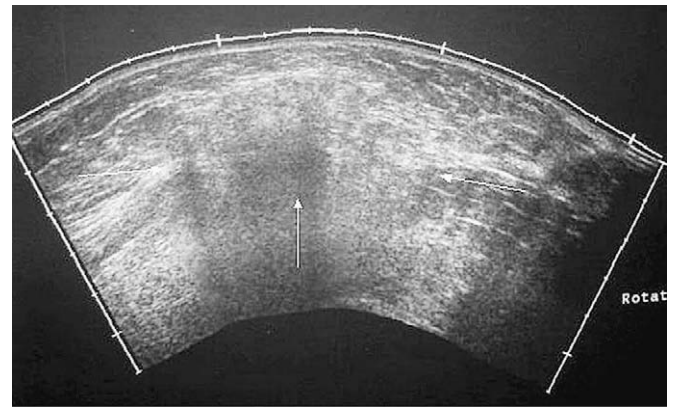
Longitudinal EFOV sonogram showing herniation of the intestinal segments through the big fascia defect (arrows). The 2 ends of the fascia defect could be included only in the EFOV image.
